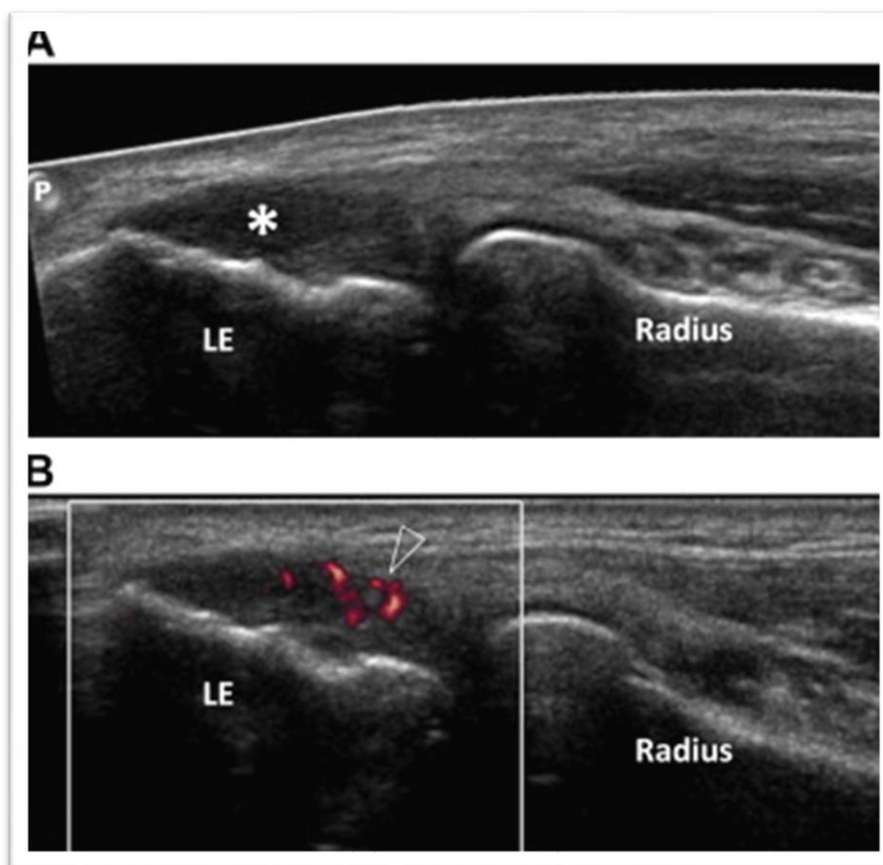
Application of Ultrasound in Sports Injury
